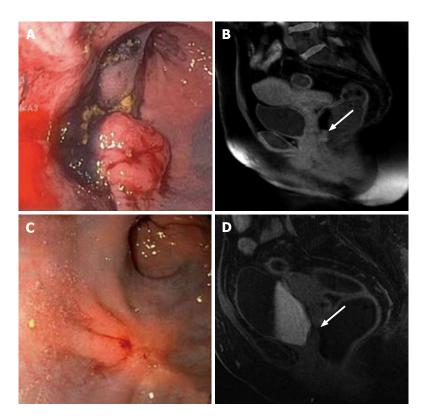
Clinical incomplete response. Evaluation of the rectal cancer prior to the initiation of neoadjuvant chemoradiation therapy by flexible sigmoidoscopy (A) and MRI (B, white arrow: Tumor). Evaluation of 7 wk after completion of neoadjuvant chemoradiation therapy. The tumor has decreased in size; however, it continues to be present as evidenced by flexible sigmoidoscopy (C) and MRI (D, white arrow: Tumor). MRI: Magnetic resonance imaging.
